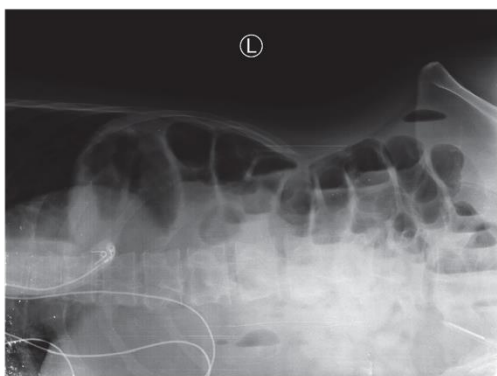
Lateral X-ray of the abdominal cavity of patient G. — signs of small bowel obstruction
